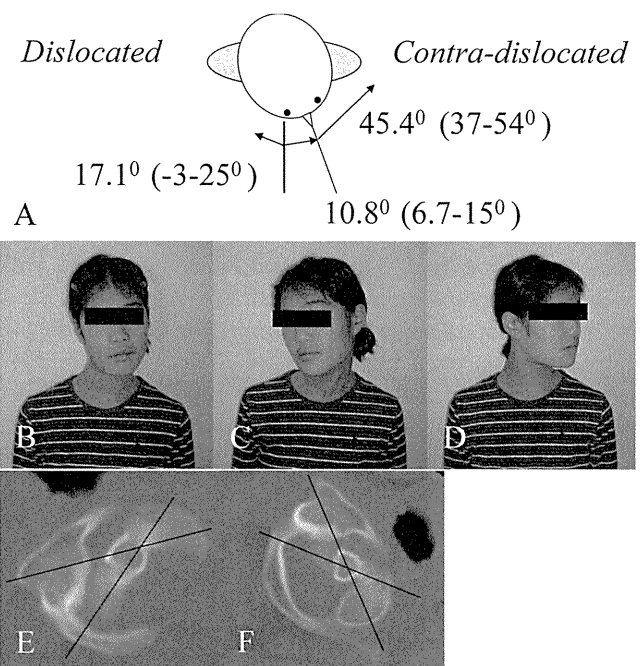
A, Averaged angles of neck rotation on pretreatment dynamic CT images in all cases. Torticollis (so-called cock-robin posture) (B) limitation of neck rotation (C, D) at the initial visit. The pretreatment dynamic CT images under awake condition forcing the maximum rotation to both sides reveal that the separation angle between C1 and C2 are fixed (E, F).
